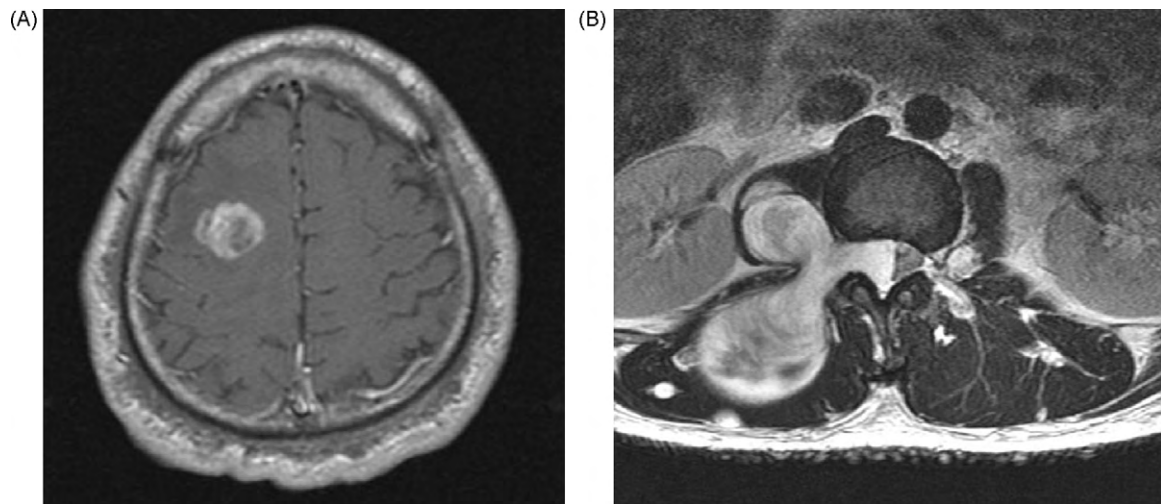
(A) Postcontrast T1W axial magnetic resonance image (MRI) demonstrated a well-enhanced lesion with central hypointensity accompanying peritumoral edema in the right frontal lobe. (B) Spinal T2W axial MRI showed a lobulated lesion in the upper lumbar region.
